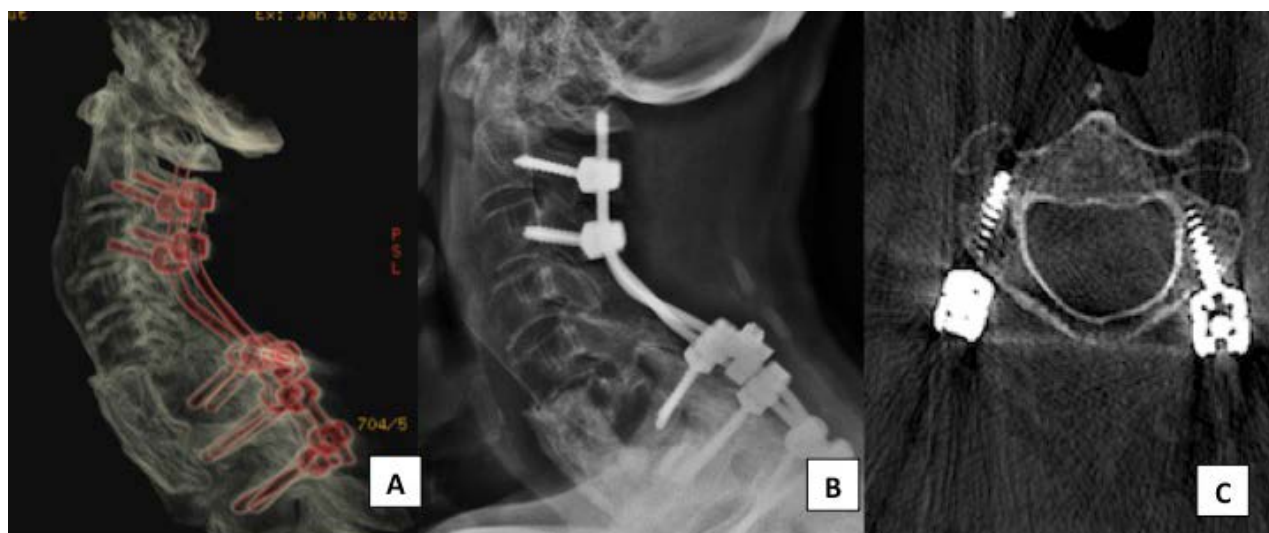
A cervico-thoracic fusion for treatment of a post-laminectomy defect. (A) Sagittal CT scan reconstruction, (B) post-operative lateral X-ray and (C) axial CT scan showing a right C2 pars screw and a left C2 pedicular screw.
